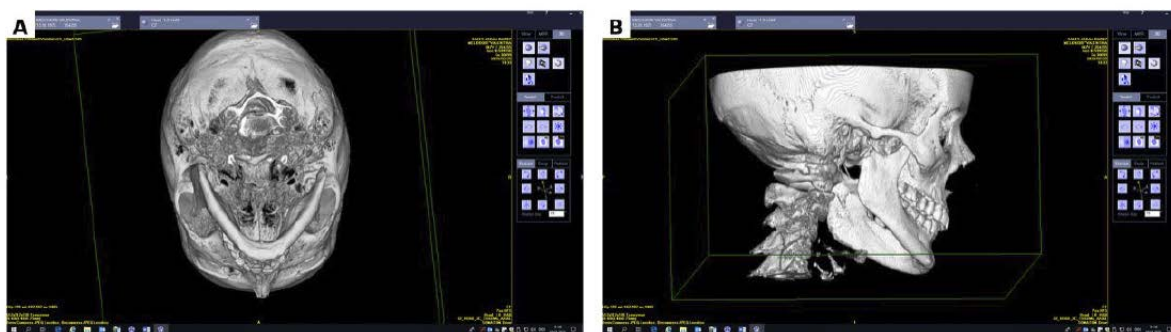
Preoperative three-dimensional CBCT reconstructions of the right condylar fracture with medial dislocation. A, inferior/axial view. B, lateral view.
